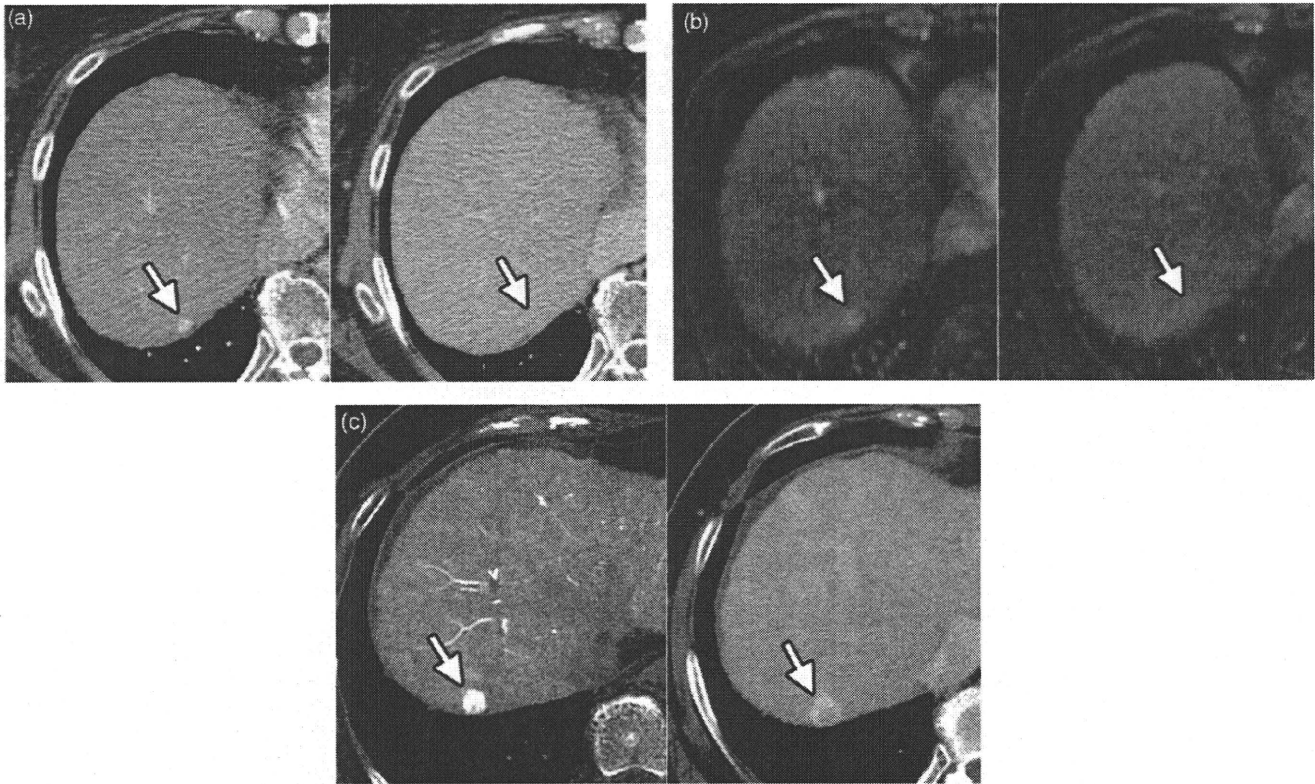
A 73-year-old female with C-virus related liver cirrhosis with multiple small hypervascular HCCs. (A) Arterial dominant phase of dynamic CT shows a tiny hypervascular nodule around 4 mm in diameter at S7 (left, arrow). It cannot be identified on equilibrium phase (right, arrow). (B) It also shows nodular enhancement on arterial dominant phase of dynamic MRI (left, arrow) without showing wash out on equilibrium phase (right, arrow). (C) Early-phase of CTHA clearly demonstrates it as hypervascular nodule (left, arrow), and it is depicted as a slightly hypodense nodule with surrounding corona enhancement (wash out) on late-phase (right, arrow).
